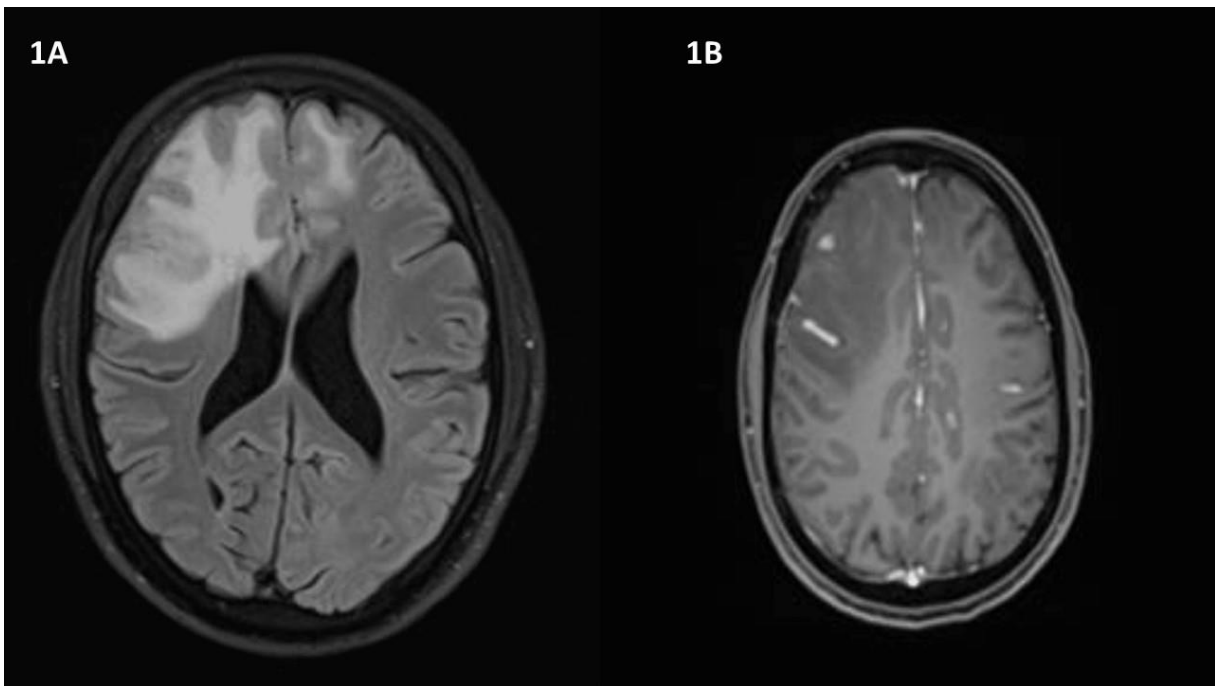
A: Magnetic resonance imaging T2 FLAIR (fluid-attenuated inversion recovery)- axial sequence showing bifrontal white matter edema (right >left) and mild focal cortical thickening. Figure1B: Magnetic resonance imaging T1 post-contrast image.
